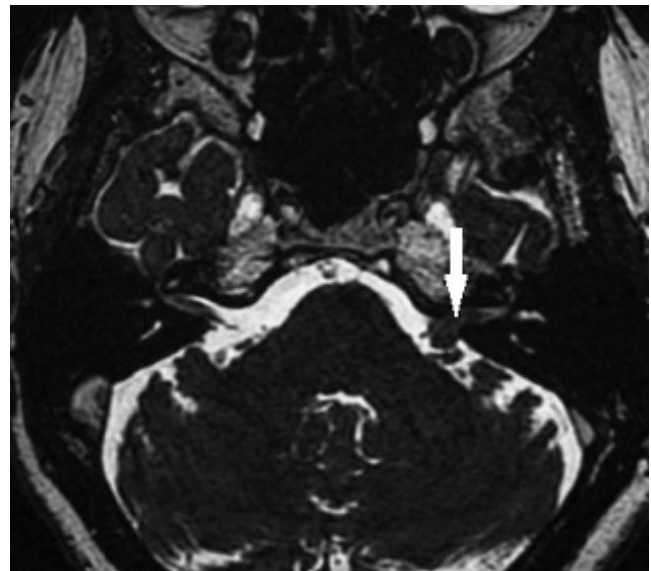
Axial CISS MRI showing left sided vestibular schwannoma (arrow), with intra-cannalicular and cisternal component, but no brainstem compression.
